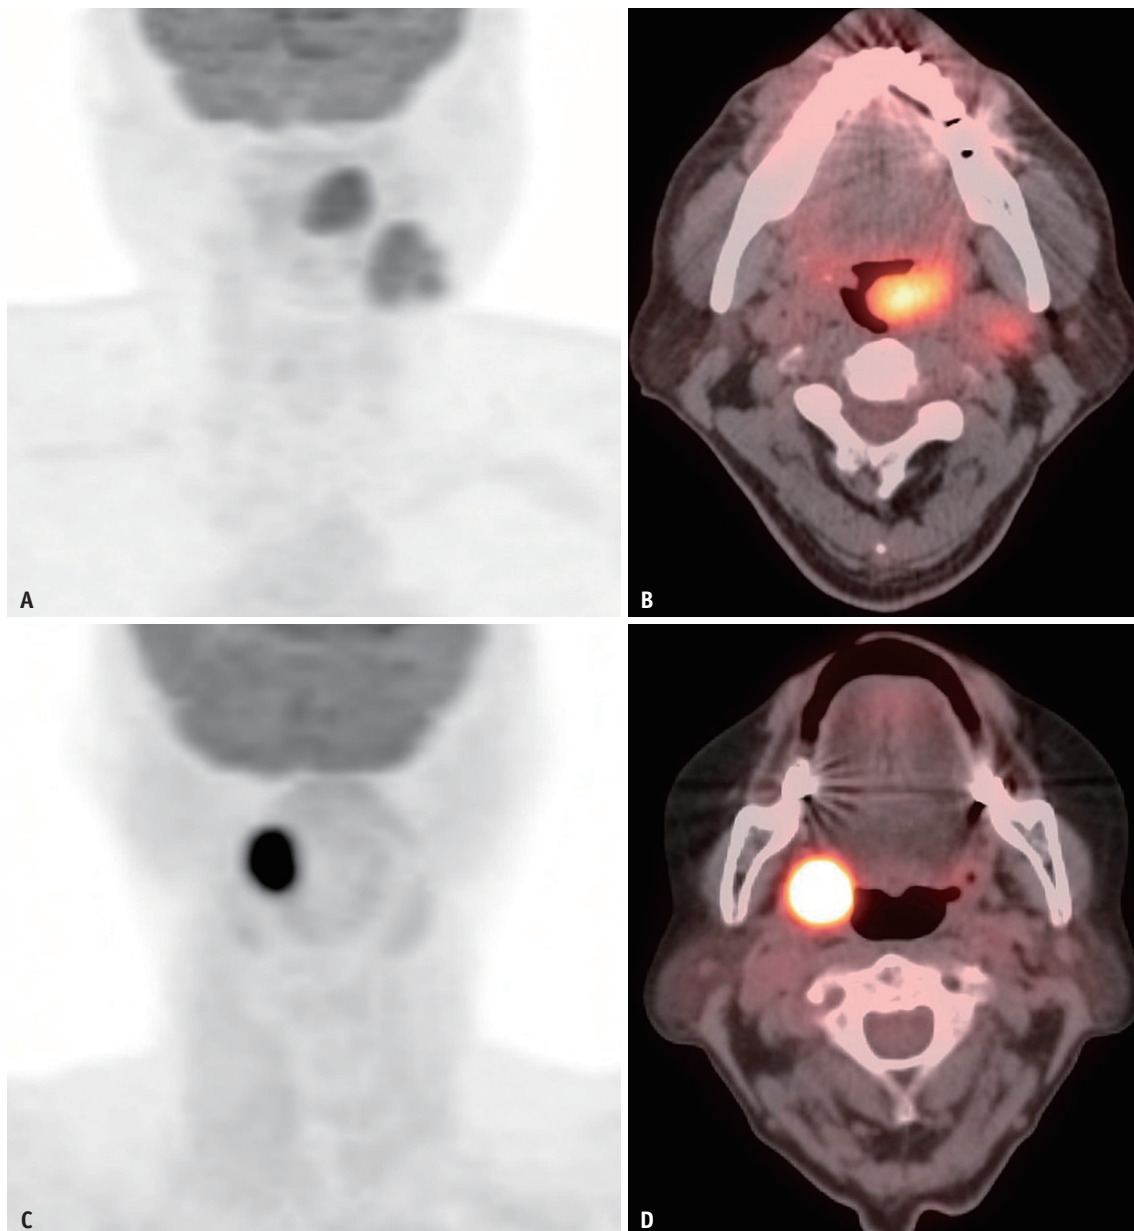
Two representative cases show the different characteristics of HPV-associated OPSCC and HPV-negative OPSCC in ^{18}F -FDG PET/CT.
